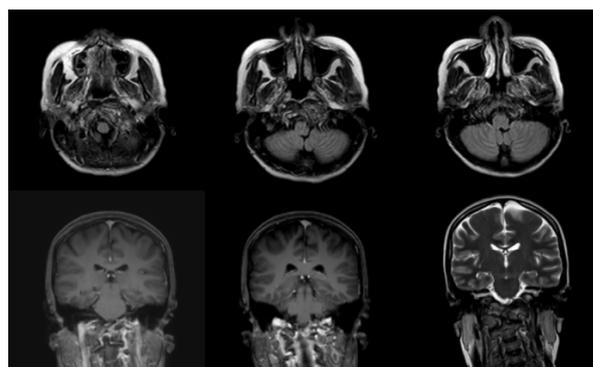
Contrast enhanced brain MRI revealing thickening and enhancement of the left soft tissue adjacent to the atlantoaxial joint, and pathological enhancement of the left clivus
